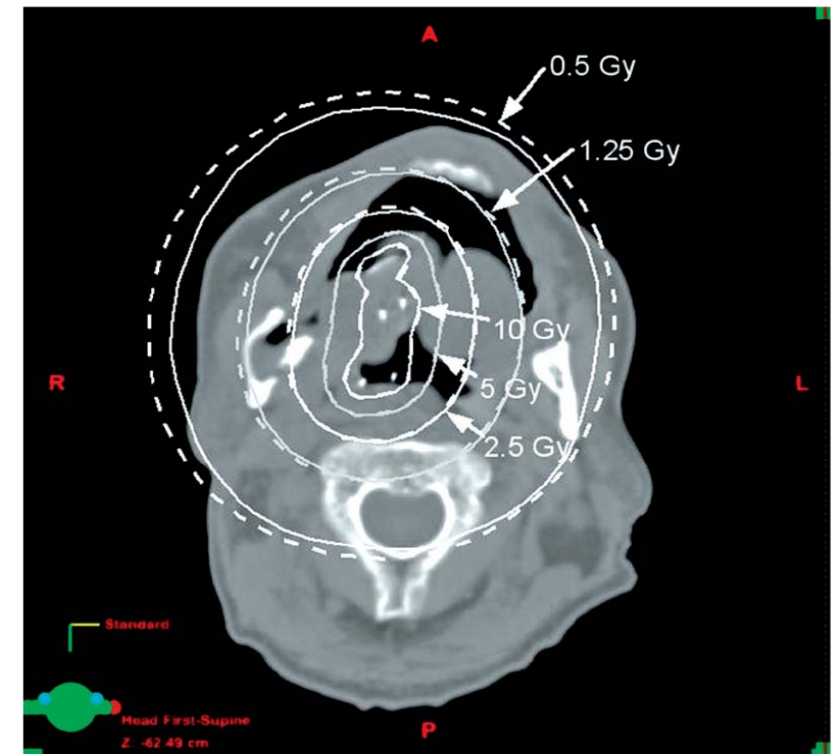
Transversal CT slice of a patient with mandibular cancer with infiltration of the floor-of-mouth and tongue using a single prescription dose of 2.5 Gy. Dotted isodose lines represent doses of TG-43 formalism, whereas straight lines show isodose lines of computations of the GBBS algorithm
